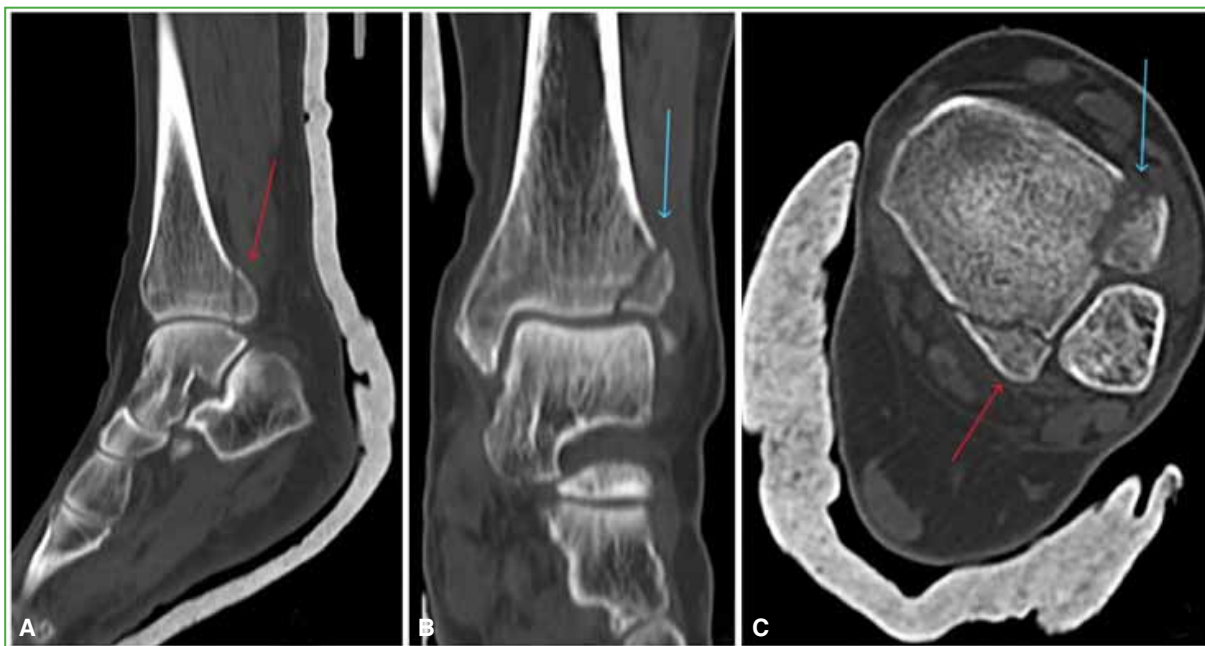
Computed tomography of the left ankle. A. Sagittal section showing a posterior malleolus fracture (red arrow). B. Coronal section showing an anterolateral malleolus fracture (blue arrow). C. Axial view showing simultaneous fractures of the Volkmann fragment (red arrow) and the Tillaux-Chaput fragment (blue arrow), with involvement of the fibular notch.
